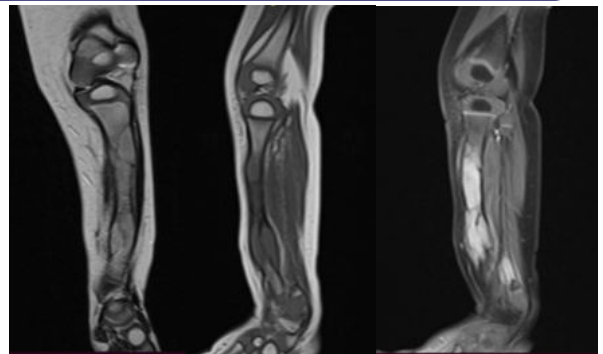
A. Coronal T2-weighted image shows intermediate signal intensity mass
